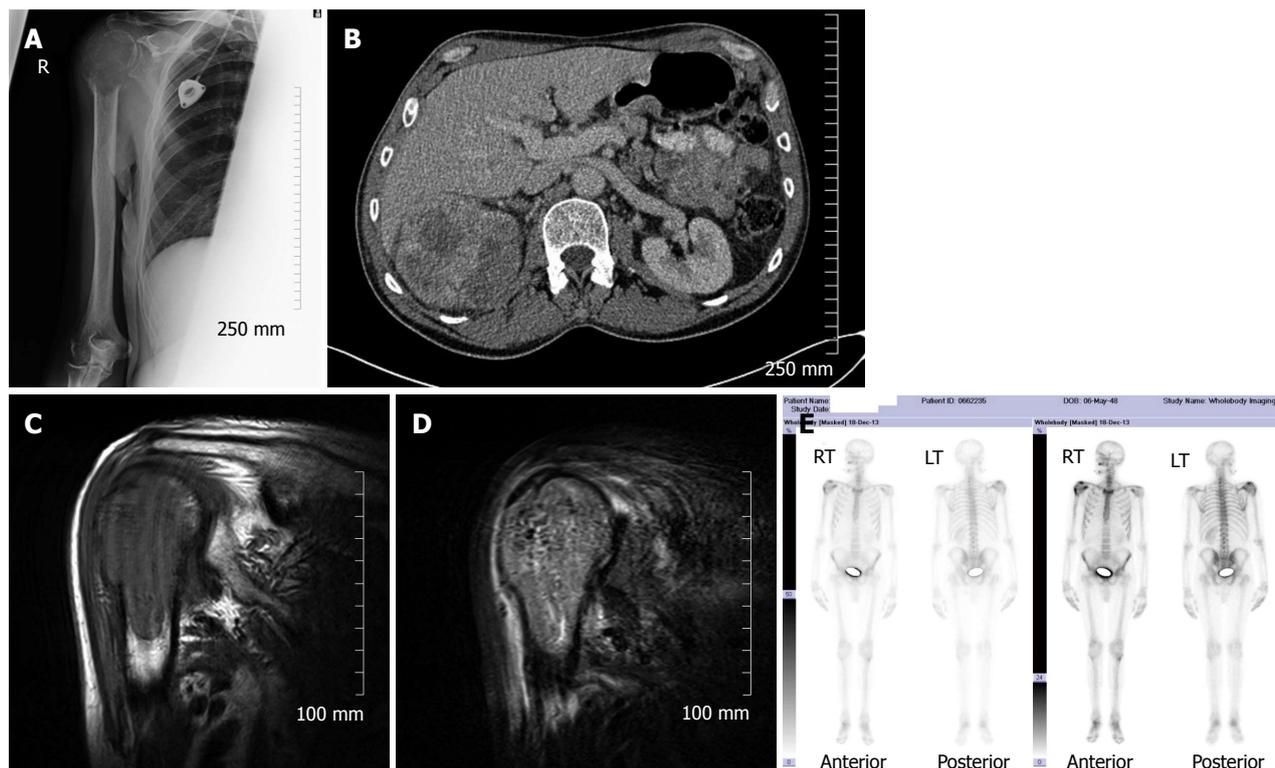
Lytic bone metastases are poorly demonstrated on bone scintigraphy. Plain radiograph (A) demonstrating a lytic metastatic deposit in the right proximal humerus in a patient with a large right renal cell carcinoma (B); Corresponding abnormal low T1 and high short tau inversion recovery signal on magnetic resonance imaging (C and D); Only the small osteoblastic component of the metastatic deposit demonstrates abnormal accumulation of radiotracer on bone scintigraphy (E).
